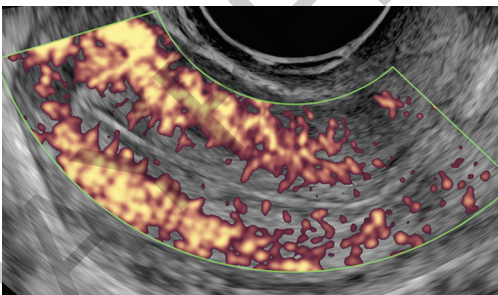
Power Doppler of receptive endometrium.
